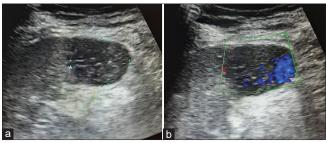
(a) Longitudinal ultrasonography image demonstrating a well-defined iso- and hypoechoic mass lesion involving the superior pole of the spleen. (b) Longitudinal ultrasonography image demonstrating intense color uptake on Doppler study consistent with rich vascularity of the splenic lesion
